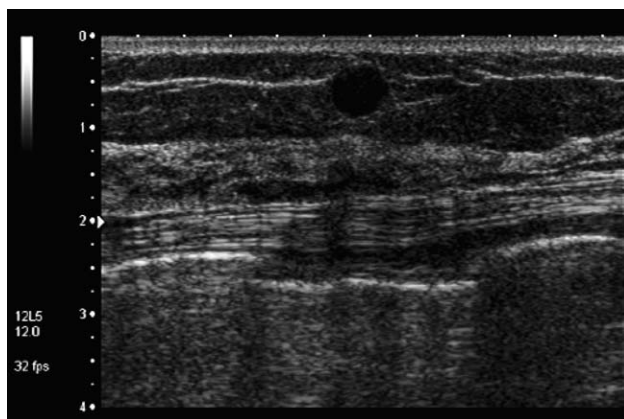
Sonography revealed an oval-shaped, well-demarcated, hypoechoic solid mass at the left upper external breast quadrant in subcutaneous tissue abutting the skin.
